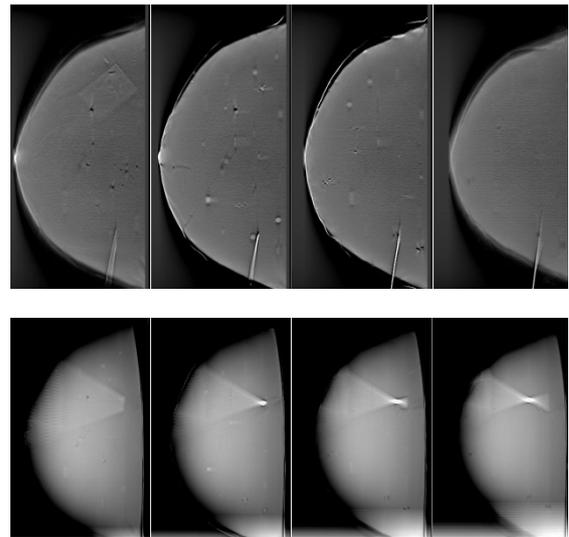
Typical out-of-plane artifacts from high-attenuation objects at consecutive heights in the reconstructed volume. Top: needle insertion position is parallel to the X-ray emitter motion lane. Bottom: Needle insertion direction is perpendicular to the X-ray emitter motion lane. Pictures courtesy of Siemens Healthcare Sector.
